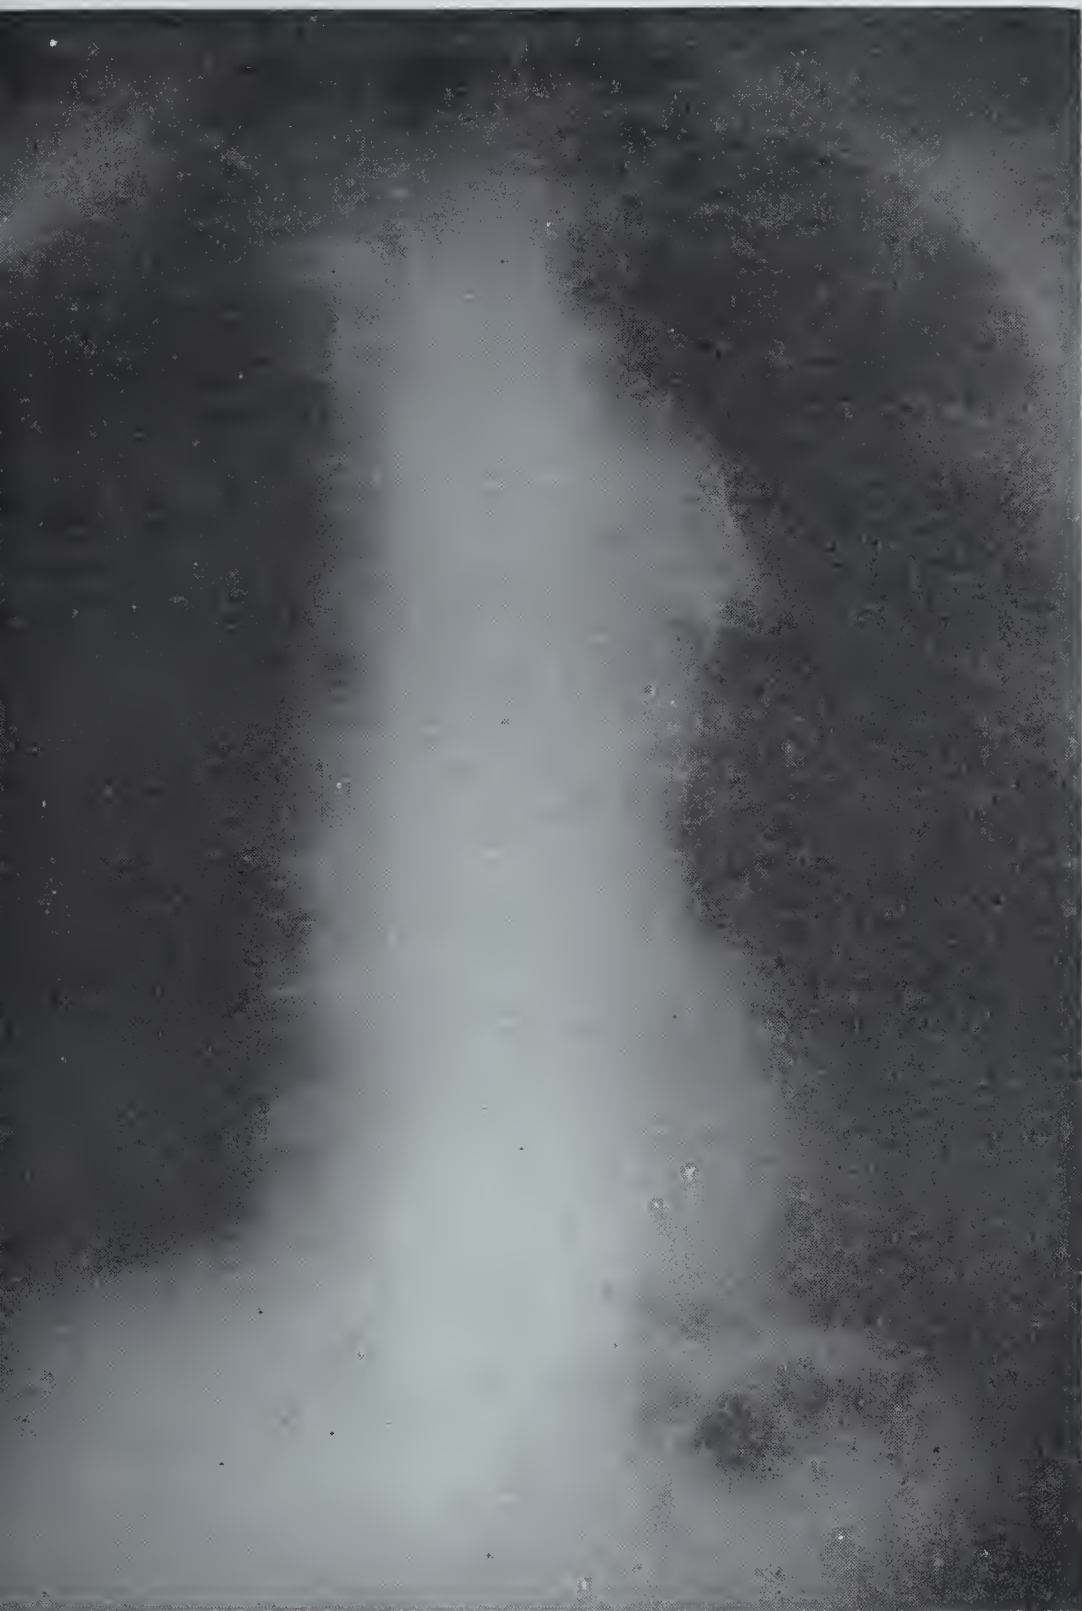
Case No. 1. X-ray showing aortic aneurysm with rim of calcification.
